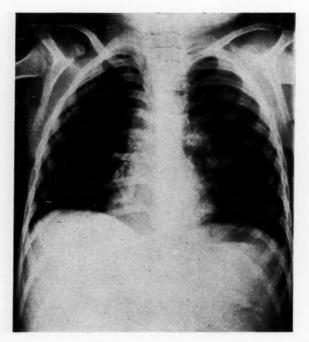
Case 3.—Roentgenogram made at the time of discharge after the first admission. The emphysema has disappeared and the lungs are clear to physical examination.
